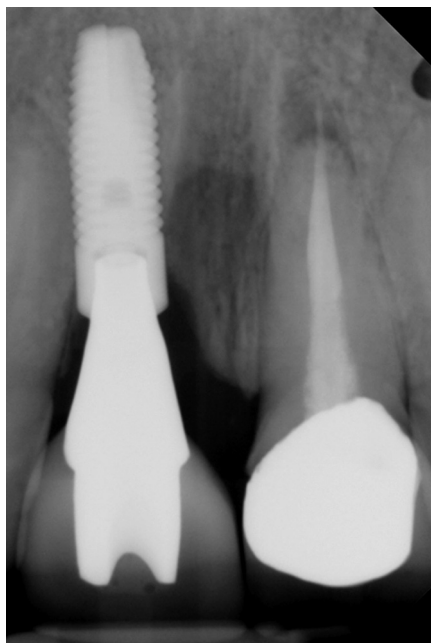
Preoperative periapical radiograph showing 1-piece zirconia abutment.
